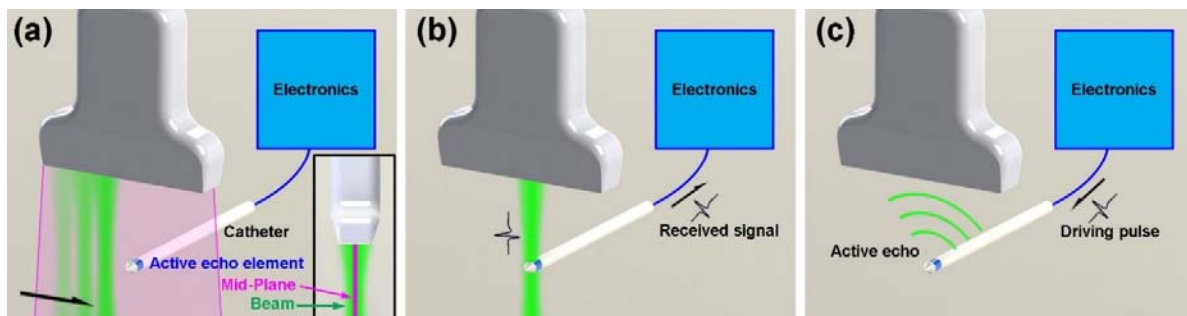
The mechanism of active echo. a) The imaging probe fires a series of ultrasound beams scanning the image region. The center plane of the image region is the mid-plane. b) When an ultrasound beam scans over the active echo element, an electrical signal is received by the electronics. c) The signal triggers the electronics, a driving pulse drives the element to fire an active echo pulse.
